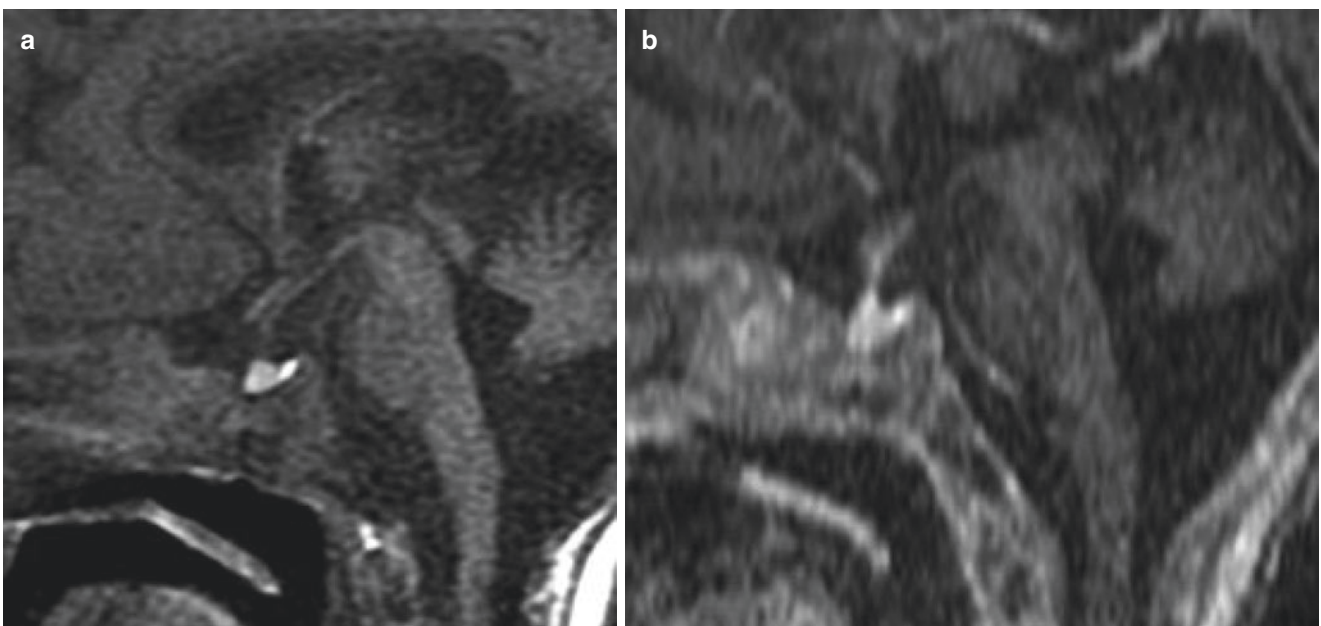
Normal anatomy of newborns. (a) T1 Sagittal pre-contrast. Anterior lobe showing hyperintensity on sagittal T1-weighted image. (b) T1 sagittal post-contrast injection. Normal enhancement of the anterior lobe as well as the pituitary stalk
